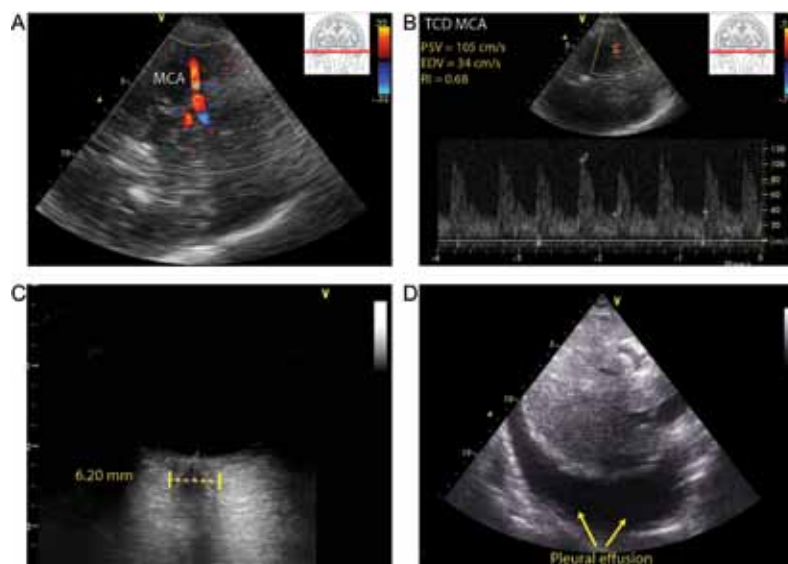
A 75-year-old man admitted to the intensive care unit for pneumonia and hypercapnic encephalopathy with right ventricular dysfunction from pulmonary hypertension. (A) Transcranial Doppler (TCD) of the right middle cerebral artery (MCA) showed a normal (B) resistance index (RI) of 0.68. (C) The optic nerve sheath diameter was 6.2mm and (D) using a left subcostal view, a pleural effusion was diagnosed. This imply that the dilated optic nerve sheath was not related to acute increase in intracranial hypertension but possibly secondary to an edematous state associated with right ventricular dysfunction.
